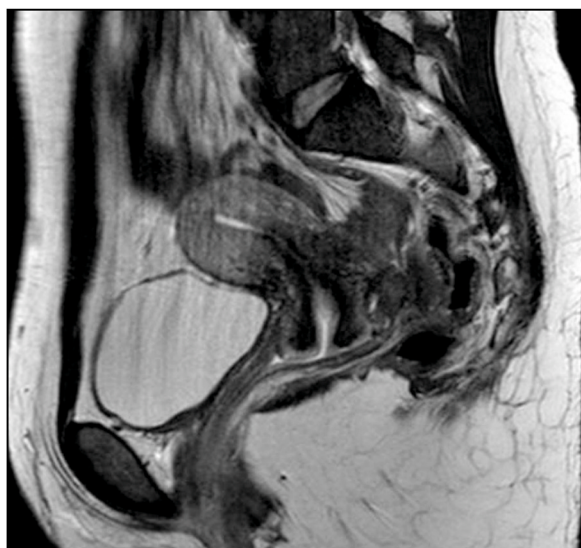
Magnetic resonance imaging (T2 sagittal view) showing external uterocervical adenomyosis with involvement and hyperplasia of the bowel muscularis. Arrows clearly show the presence of cervical adenomyosis infiltrating the rectal muscularis (reprinted from 17).
